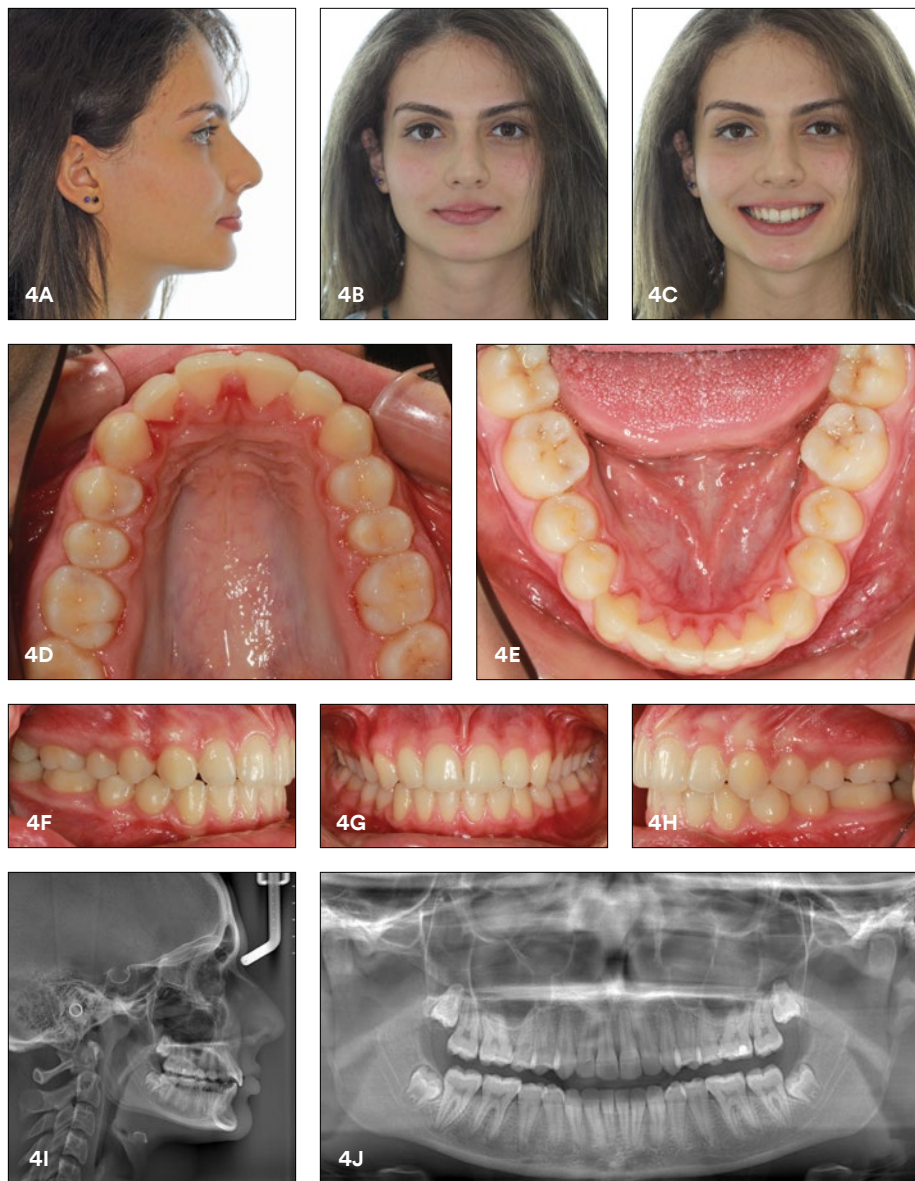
Post-treatment photos and radiographs.
